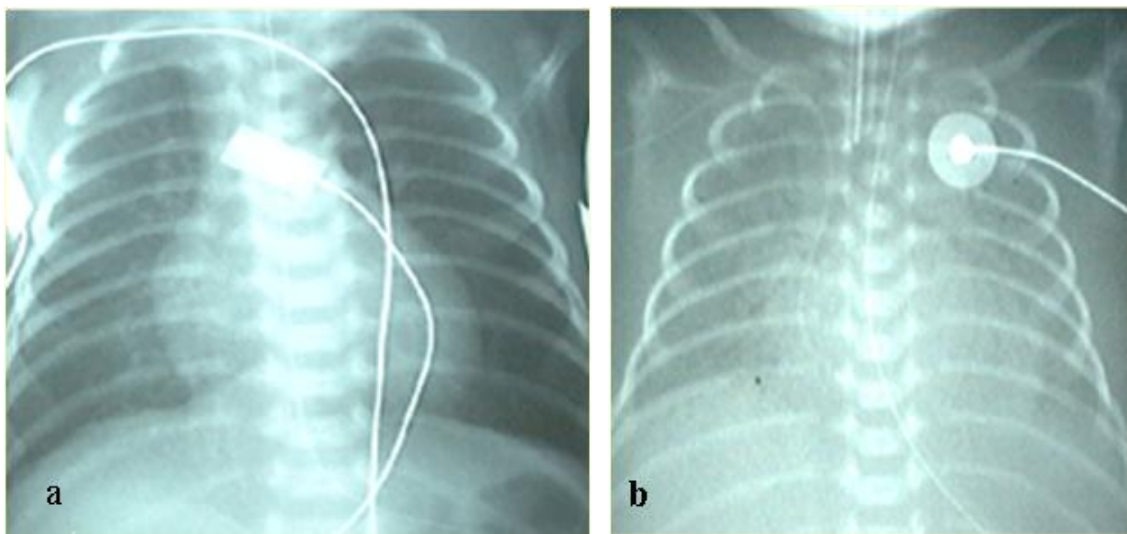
Chest X-ray films demonstrate the radiological features of RDS. A normal x-ray (a) has clearly visible heart and diaphragmatic borders with translucent lungs. In RDS (b), the lung is opaque with a characteristic 'ground-glass' appearance
